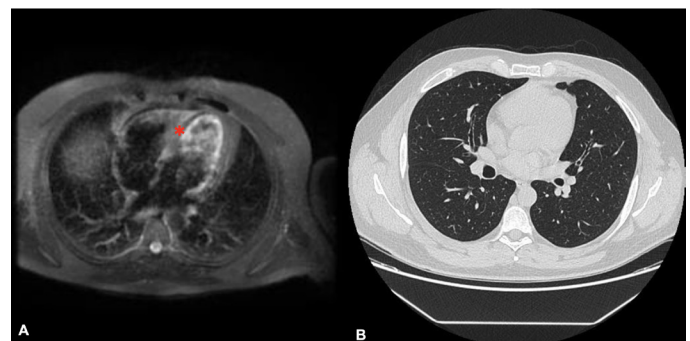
Cardiac magnetic resonance and thorax computed tomography examinations (CT) of the same patient. Subendocardial patchy contrast enhancement(asterix) is observed in the late contrast series on the left(A). Widespread involvement due to COVID-19 pneumonia on the right (B).
